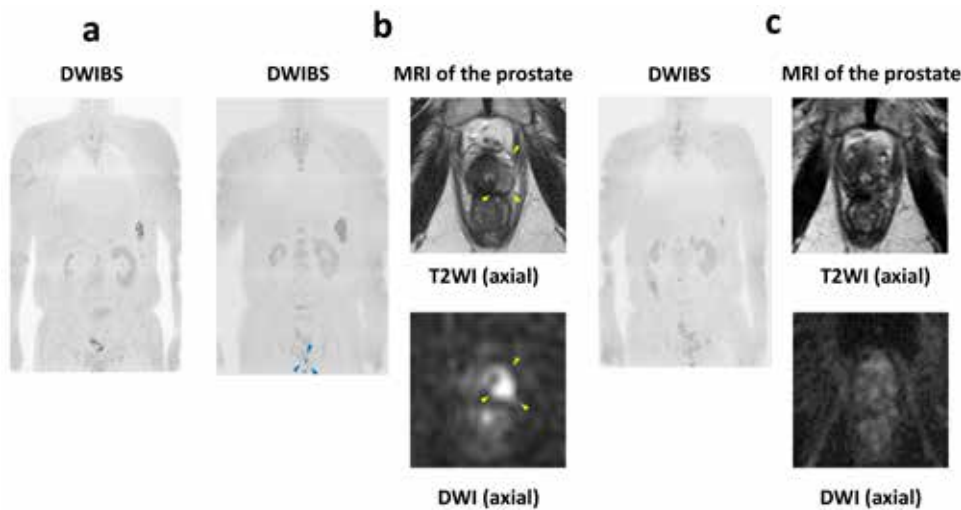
After docetaxel therapy, no worsening of metastasis was registered on diffusion-weighted whole-body imaging (DWIBS) (Fig. 2a). Before the treatment with high-intensity focused ultrasound (HIFU), a high-signal region was detected in the left lobe of the prostate on DWIBS and MRI of the prostate (Fig. 2b). At 12 months after left hemi-ablation with HIFU, there was no cancer suspicious region on DWIBS and MRI of the prostate (Fig. 2c).
